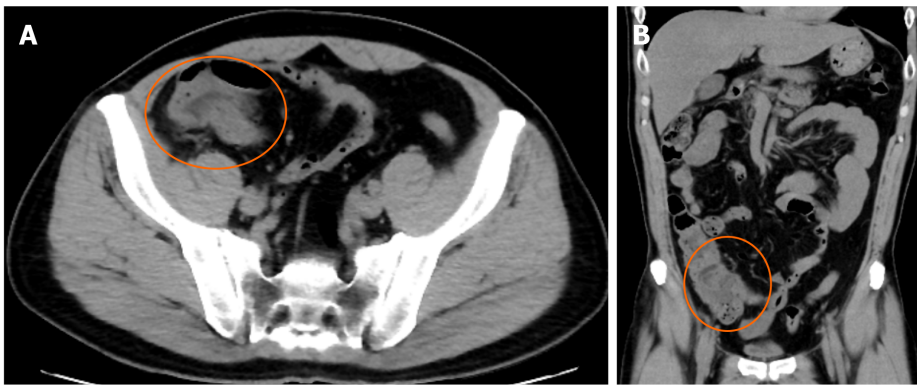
Computed tomography scans of the abdomen. Ileocecal wall thickening (circled) is evident in the horizontal and coronal views. A: Horizontal view; B: Coronal view.
